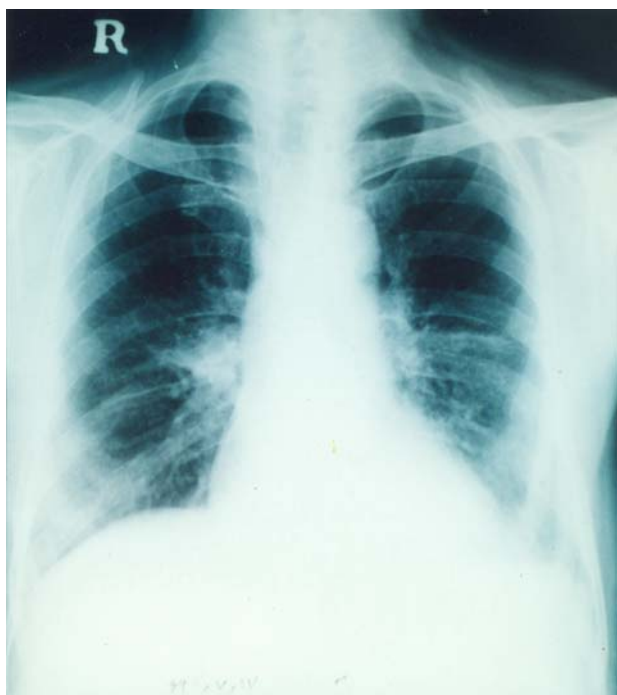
Chest X-ray of a 75 year-old nonsmoker male farmer who worked as a cook, baker and gardener. Note the hilar opacities and streaky paracardiac shadows mainly on the right side with downward displacement of the interlobar fissure. He used to enjoy burning twigs and sweepings in his garden for both heating and disposal. He became gradually dyspneic on walking uphill. Widespread anthracotic plaques were found on bronchoscopy
